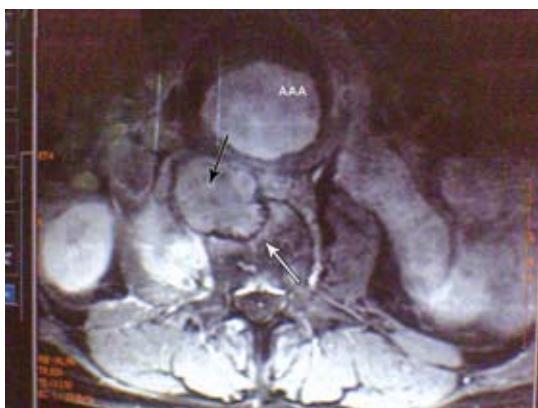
An MRI showing the abdominal aortic aneurysm (AAA) with posterior contained leak (black arrow) and chronic vertebral destruction (white arrow).
